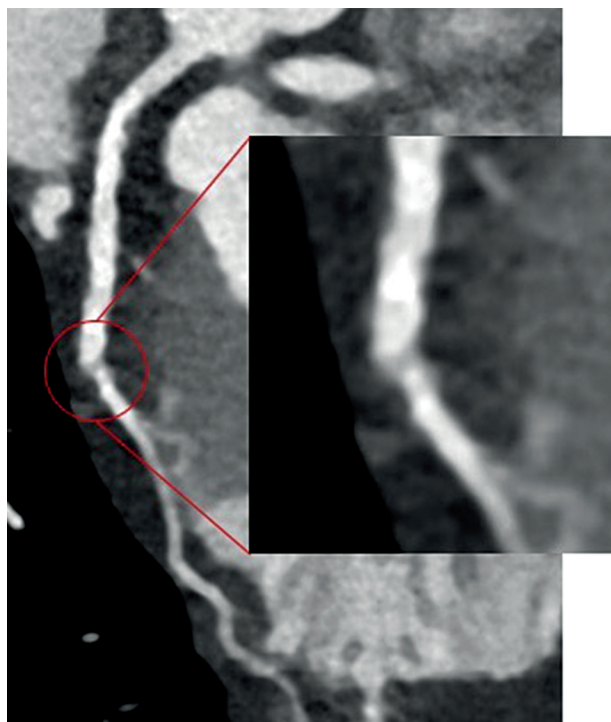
Patient with venous-graft by-pass. Coronary computed tomography angiography shows intra-stent hypodensity (arrows) in the venous graft confirmed by invasive coronary angiography (ICA). A) Curved multiplanar reformatted image with true axial sections of the vessel at stenotic level. B) Magnification of A. C) Fluoroscopic image during ICA
